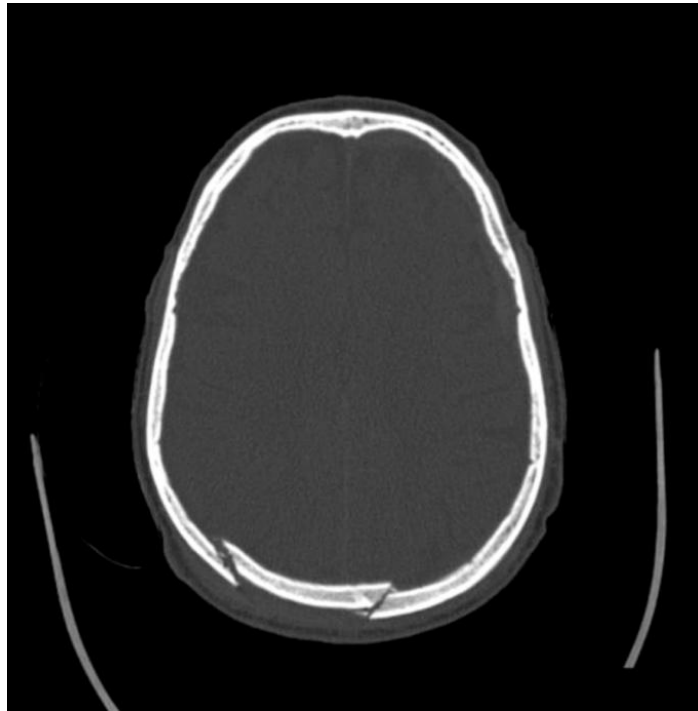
The CT scan of the Skull (bone window) showing a depressed fracture of the occipital bone. It is an example of primary and focal injury [17]
